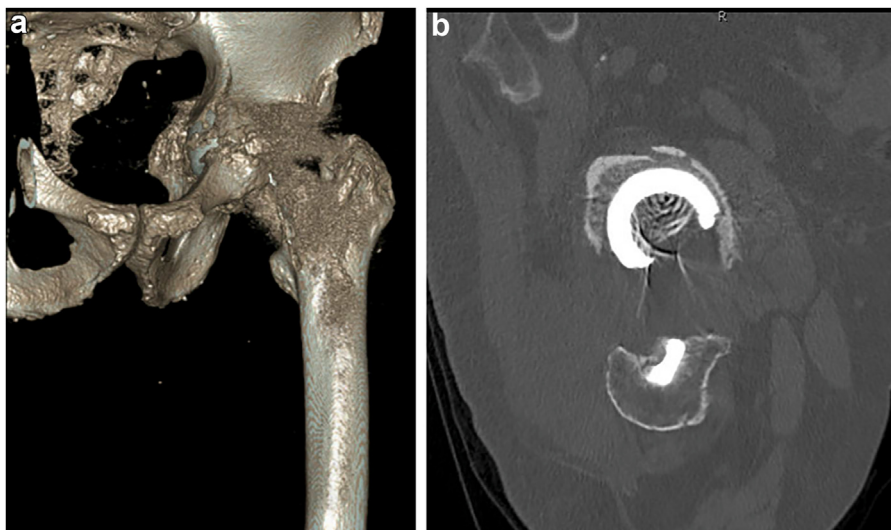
(a and b) Subsequent computed tomography (CT) image and three-dimensional reconstruction 2 years following initial arthroplasty demonstrating medialization of the acetabular components beyond the medial wall of the acetabulum.
